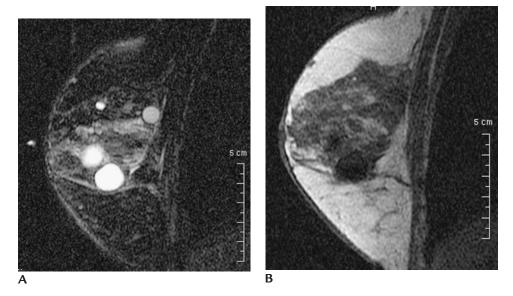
Cysts. (A) Sagittal T2-weighted fat suppressed image. Multiple masses of varying sizes characterized by bright signal. (B) Sagittal T1-weighted image, same table top position as in (A). Low signal intensity for the same masses seen on T2-weighted image. When associated with inflammatory changes, these may demonstrate rim enhancement.
